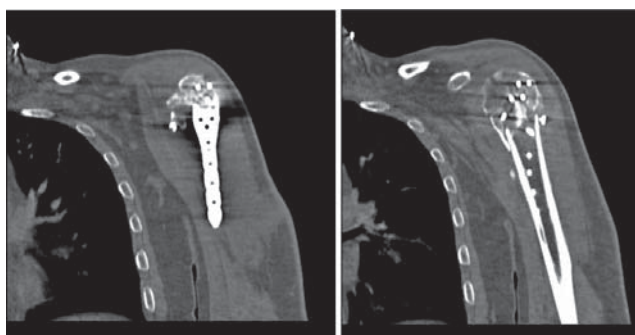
Antero-posterior radiography, CT section, 3D reconstruction of computed tomography.
